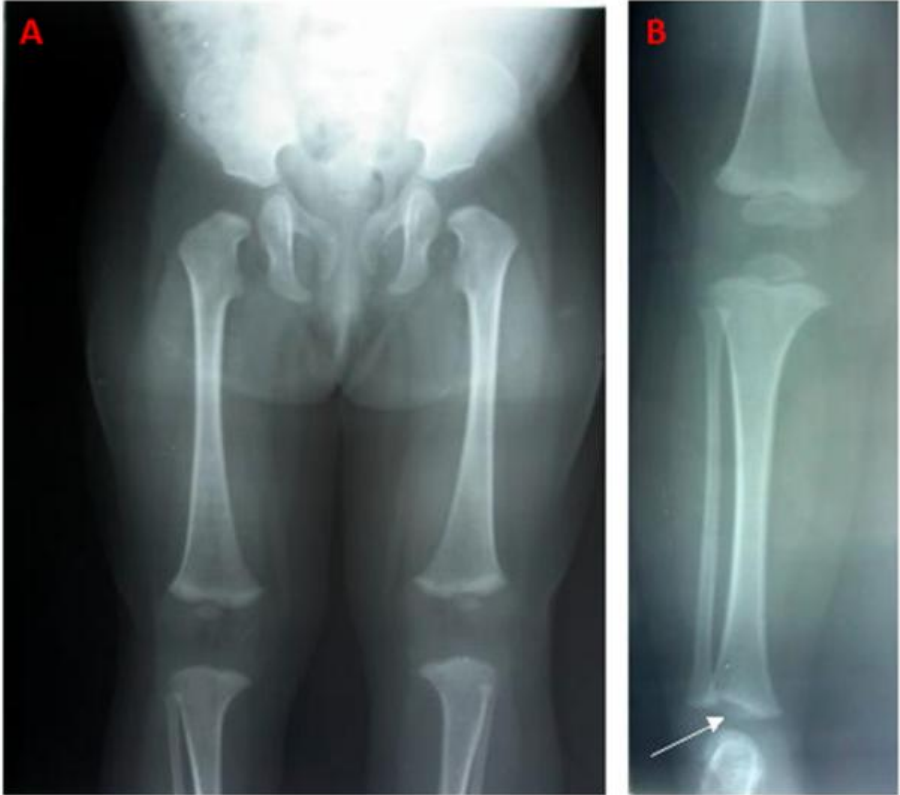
X-ray examinations of the lower limbs at 1 year (A- AP position) and 2.5 years of age (B- AP position) At 1 year of age (A) there was delayed ossification of the proximal femoral and tibial epiphyses. At 2.5 year of age (B) was detected irregular ossification of the distal metaphyses of the tibiae is noted (indicated with arrow).
